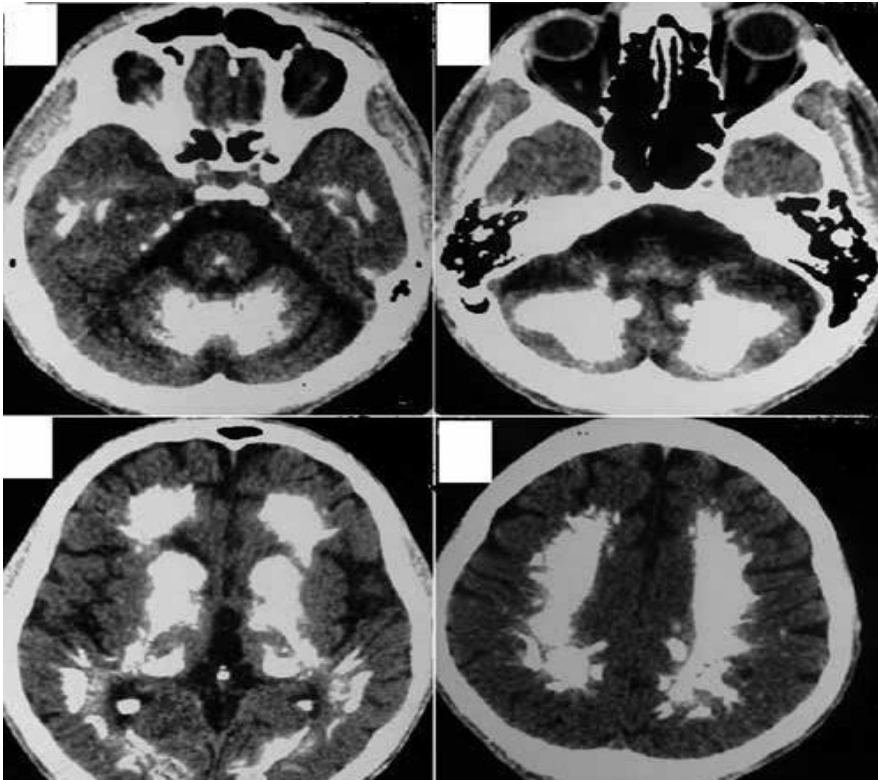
Brain CT revealing extensive calcification of: A) Cerebellar anterior lobe; midbrain; temporal periventricular white matter. B) Cerebellar white matter, including inferior cerebellar peduncles; cerebellar amygdale. C) White matter of frontal, parietal and occipital gyri, including U-fibers; internal capsule; caudate, lentiform and thalamus nuclei; choroid plexus and pineal. D) centrum *semiovale*.
